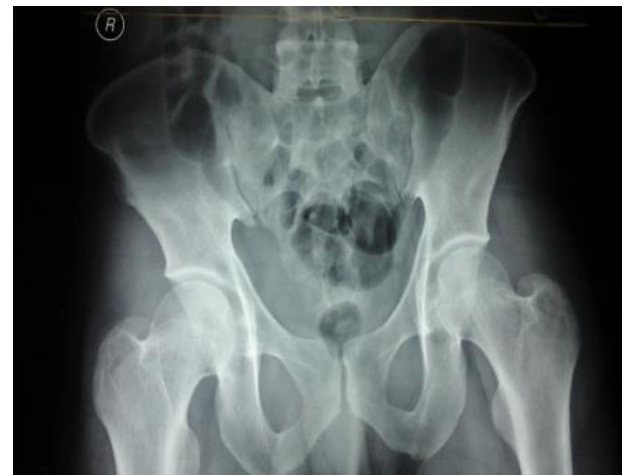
Pelvic x-ray of patient.
